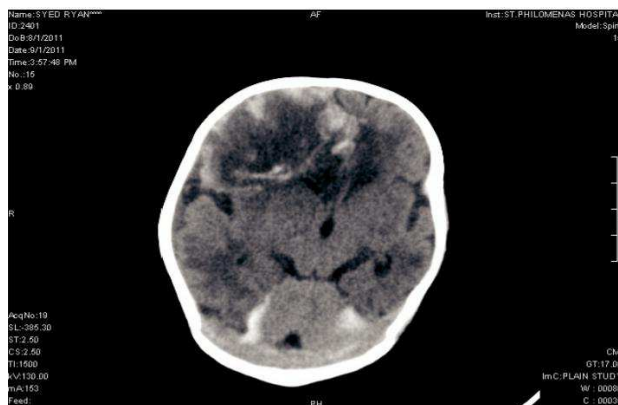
Repeat CT images of Brain done after 2days of discontinuation of FFP, Shows new subdural hematoma along with infarct involving posterior cerebral artery territory.
